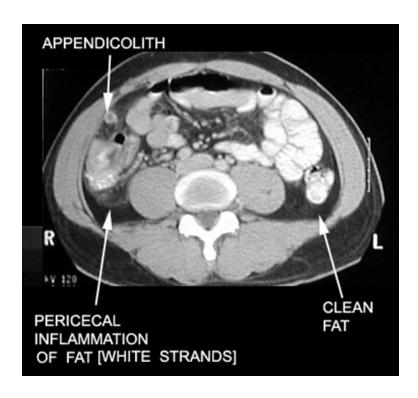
CT Showing inflammed appendix with faecolith
